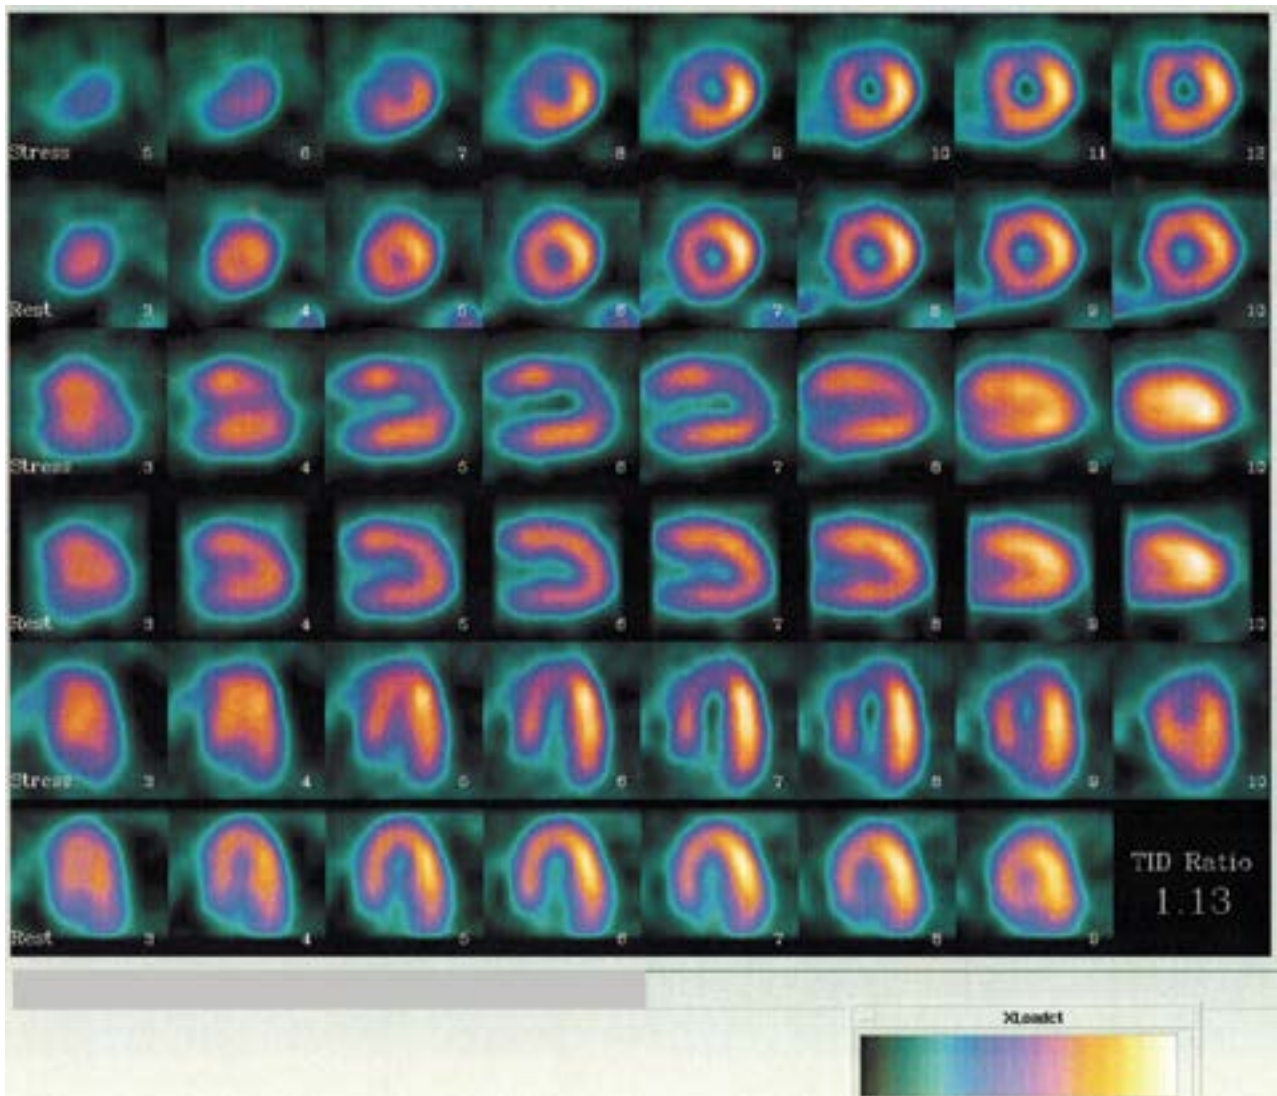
MIBG SPECT: perfusion defect in typical LAD territory
